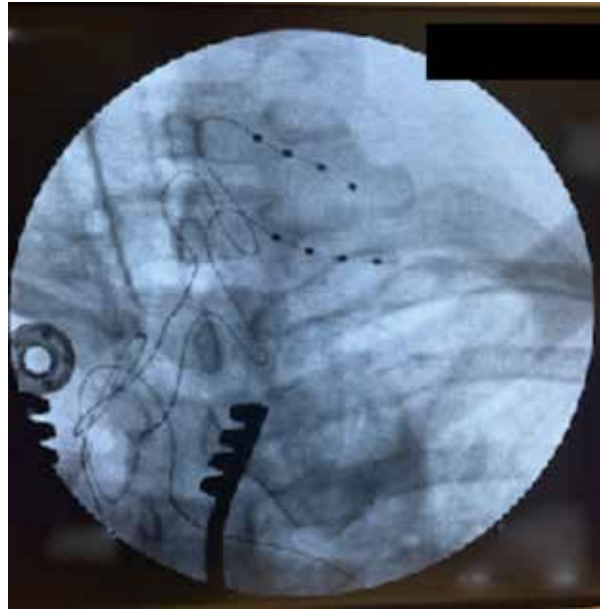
Posterior cervical-thoracic x-ray with right sided DRG tunneled leads (C8 and T1). DRG trial with external IPG.
